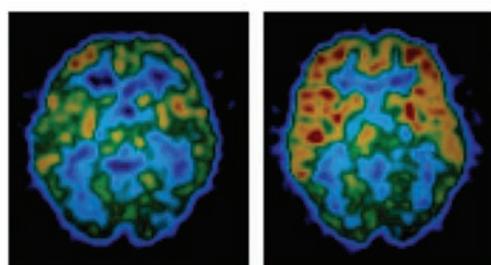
Tomographic FDG PET images in single normal volunteer. Left image was obtained under resting condition during any specific thinking. Right image was obtained under resting condition during imagining bright future of life. Positive thinking was associated with bilateral frontal lobe activation.
